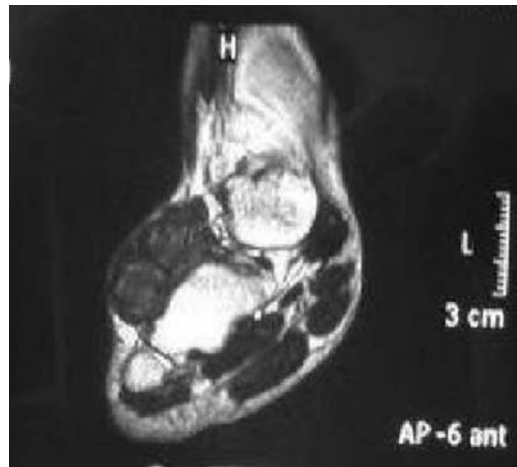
Soft tissue masses of 3×3 cm and 2×2 cm adjacent to the calcaneus are seen on MR image.
